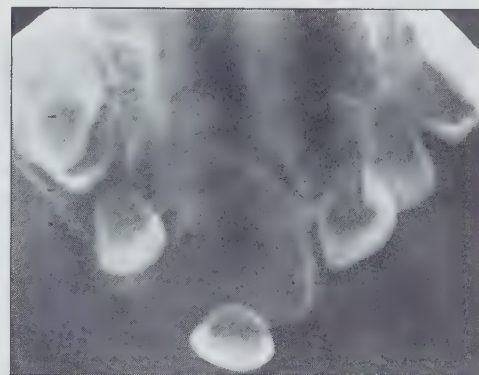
Periapical view of the premaxilla revealed a corticated, radiolucent lesion with a displaced primary right maxillary central incisor (lesion outlined with arrows).
